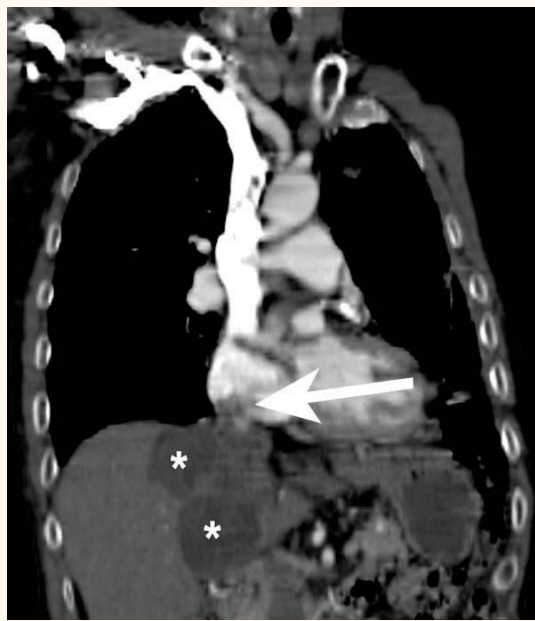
Coronal reformatted multidetector computed tomography images show cystic embolus in the right atrium (white arrow), and hepatic hypodense cystic masses (*).
